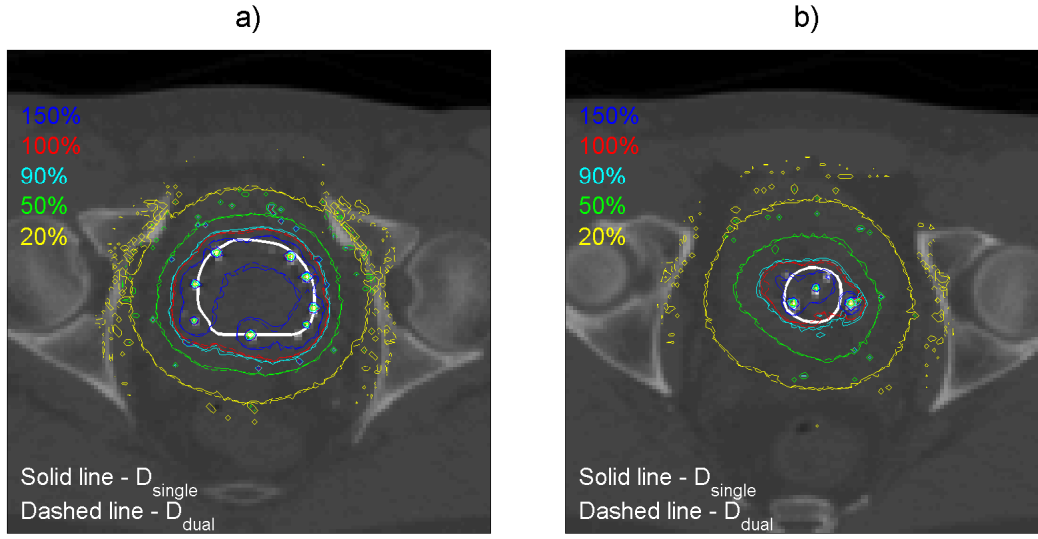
Comparison of dose distributions D_{single} (solid line) and D_{dual} (dashed line) for two CT slices. 100% isodose line corresponds to 144 Gy prescription dose. The bold white line delineates the PTV.
